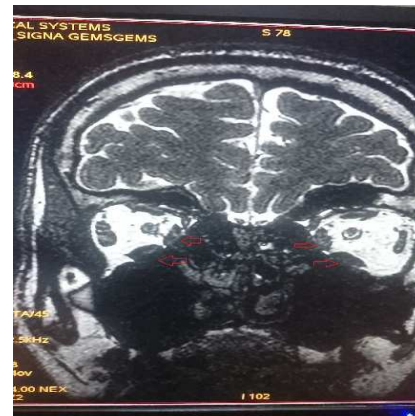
MRI skull and orbit showing hypertrophy of muscle belly of bilateral medial and inferior recti (sparing the tendons)
